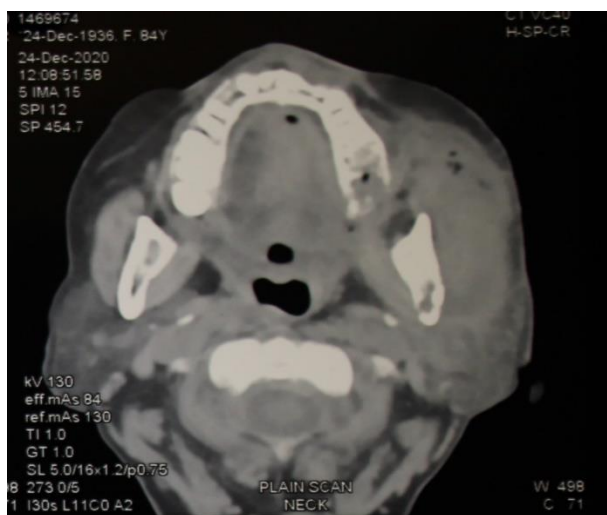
Computed Tomography Scan, (Axial Section) Showing Thickened Left Masseter Muscle and an Underlying Area of Decreased Density Representing Abscess Formation
